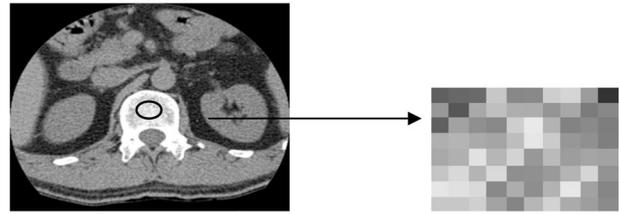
The entropy and uniformity are calculated by a computer software from a section of L1 trabecular bone on CT scan
